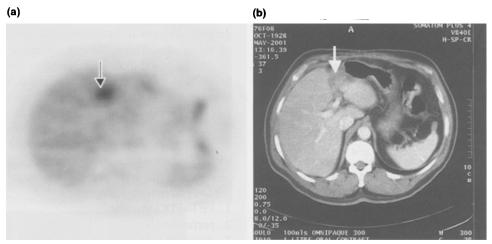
(a) FDG-PET showing focal area of increased activity in the anterior liver. (b) Corresponding CT image shows anatomical site of lesion adjacent to the falciform ligament
